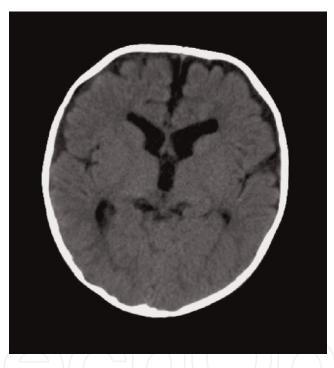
The CT scan of the brain of the child with idiopathic external hydrocephalus (adequate psychomotor development of the child, no need for a drainage procedure).
